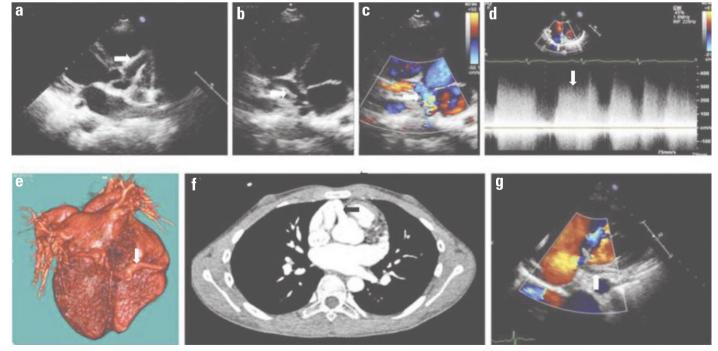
(a) TTE, left ventricular long-axis view showing the dilated RCA (arrow); (b, c) TTE, no standard of the aorta short-axis view showing different segments of the fistula (arrows); (d) TTE (color Doppler imaging), dual-phase shunt in the coronary artery fistula (arrow); (e) MDCT volumerendering reconstruction of the significantly dilated RCA (arrow); (f) MDCT multiplanar reconstruction demonstrating a connection between RCA and coronary sinus (arrow); (g) TTE, four-chamber view displaying no shunt at the primary coronary artery fistula postoperatively
